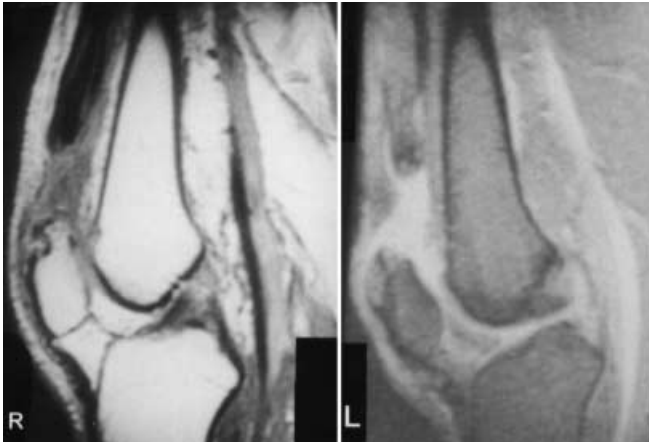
MRI of the right and the left knees showing the rupture of the quadriceps tendons and fibrotic tissue between the ends
